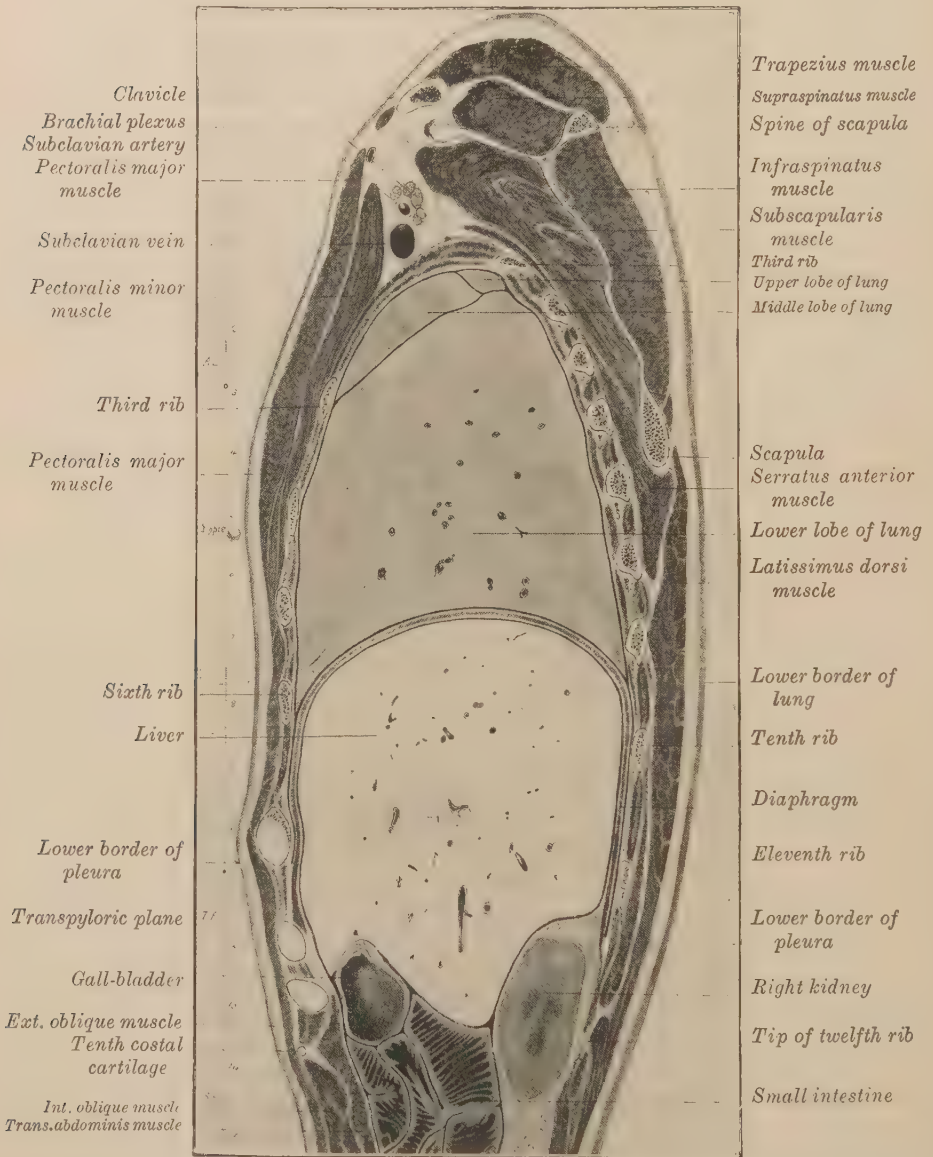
SAGITTAL SECTION OF THE TRUNK OF A MAN AGED FORTY YEARS, MADE IN THE LINE OF THE RIGHT NIPPLE, PASSED ABOUT 10 CM. TO RIGHT OF THE MEDIAN PLANE, VIEWED FROM THE MEDIAN ASPECT. One-third natural size. (J. S. Dickey.)
